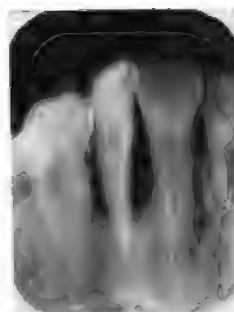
Pyorrhea. Large pocket around lateral incisor not demonstrable until roentgenogram was taken.
